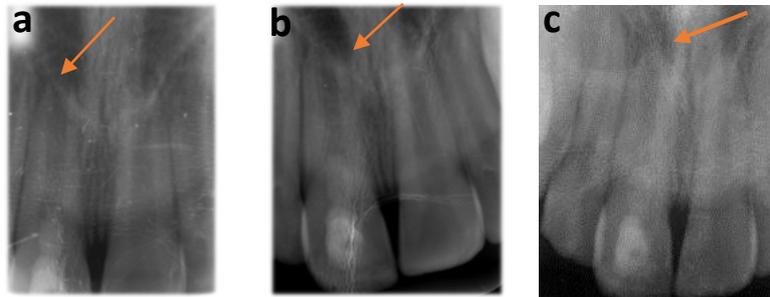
a: 6-month radiograph; b: 1-year radiograph; c: 3-year periapical radiograph
